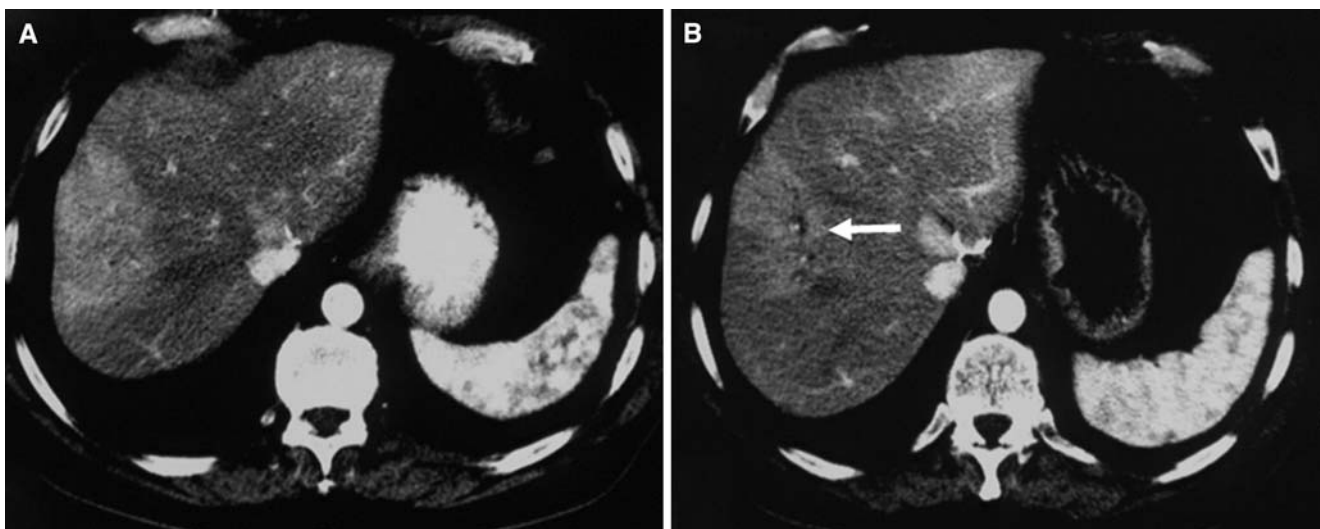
A 63-year-old man with cholangiocellular carcinoma. (A) CT artery phase demonstrates only a sectorial hyperdense area without a clear explanation. (B) Three months later, at artery phase CT, a bile ducts dilation can be observed as well (*arrow*).
